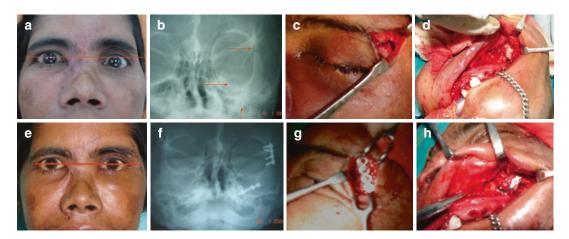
Two point fixation of Zygomatic complex fractures. (a) Preoperative photo showing the lowering of the left eyeball due to downward and outward displacement of Lt Zygomatic complex. (b) Preoperative PNS View Xray showing the frontozygomatic dysjunction and downward displacement at zygomatic buttress and infraorbital margin. (c) Intraop photo showing the frontozygo
